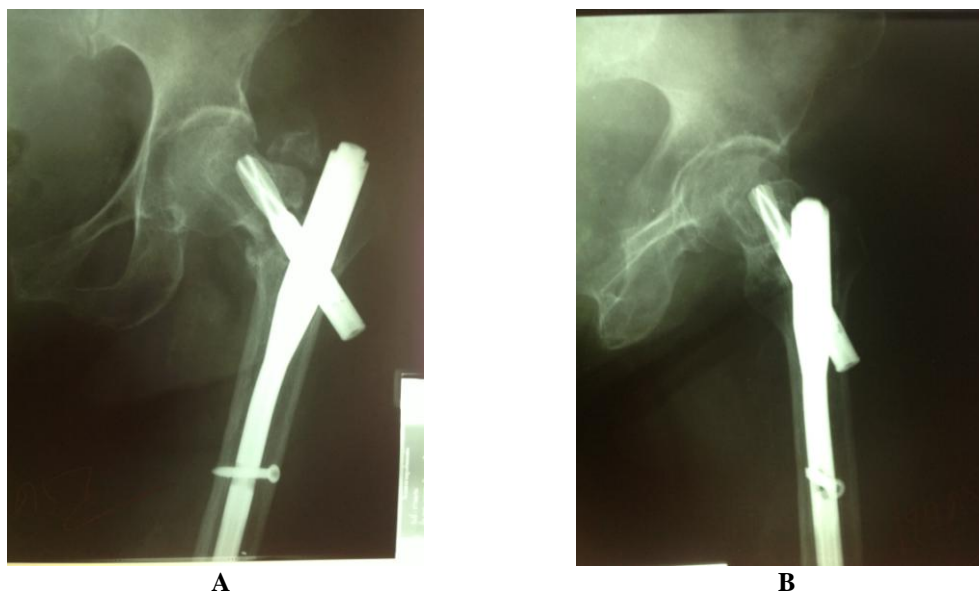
Postoperative anteroposterior (A) and lateral (B) radiographs of a 70-year-old woman with an AO/OTA 31-A2 -type trochanteric fracture indicating instrument failure
